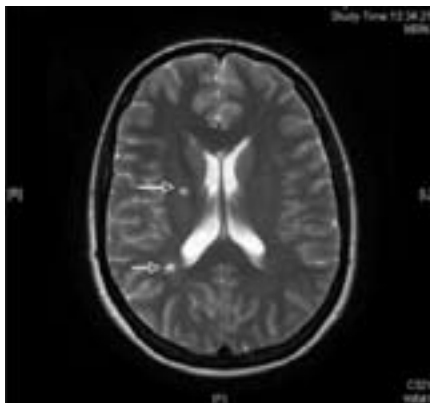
(a): T2-weighted axial MRI brain showing high signal lesions in the right hemisphere (white arrows).
